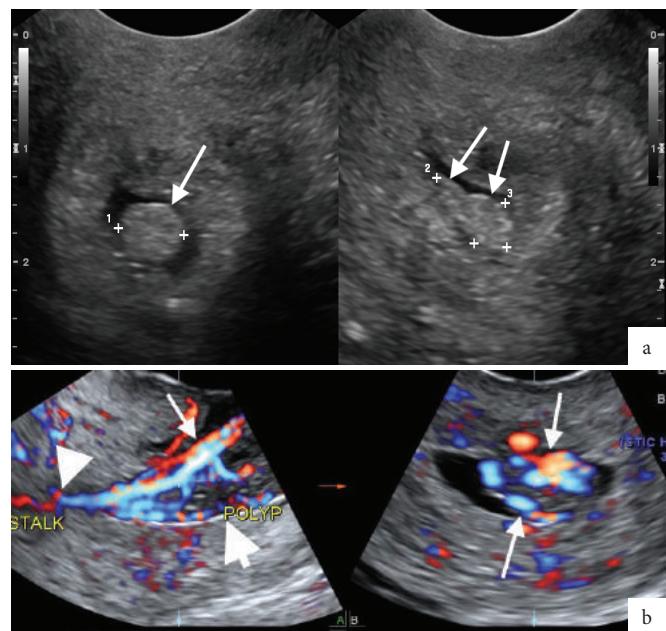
Long and short axis US scans of the cervix showing an endocervical polyp (arrows). b. Long and short axis colour Doppler US scans showing an endocervical polyp (arrows) and the vascular pedicle (arrowhead).
